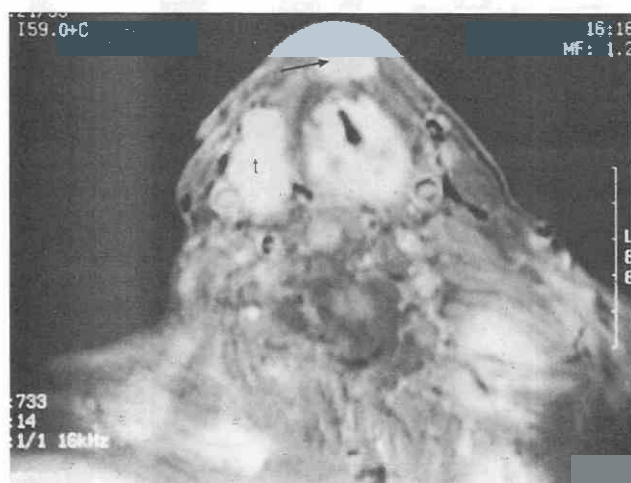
Axial T1-weighted MR postgadolinium image with fat suppression shows ovoid enhancing tissue (arrow) anterior to the larynx. The tissue, which shows the same signal intensity and enhancement as the enlarged right thyroid lobe (t), represents pyramidal lobe tissue involved by goiter (same patient as in Figure 20-27).
